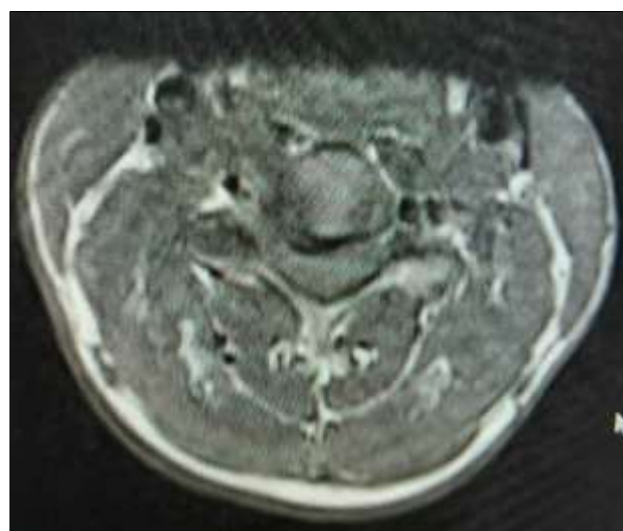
Pre operative radiographs of cervical spine
